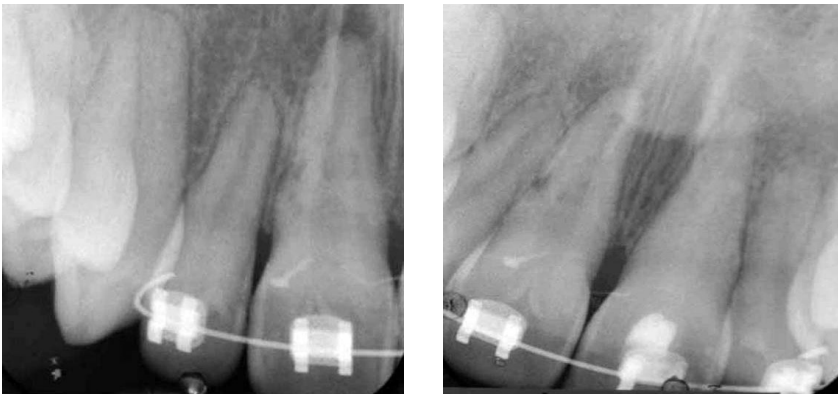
Periapical film taken post redress of 11 and 21; 9 months post trauma
